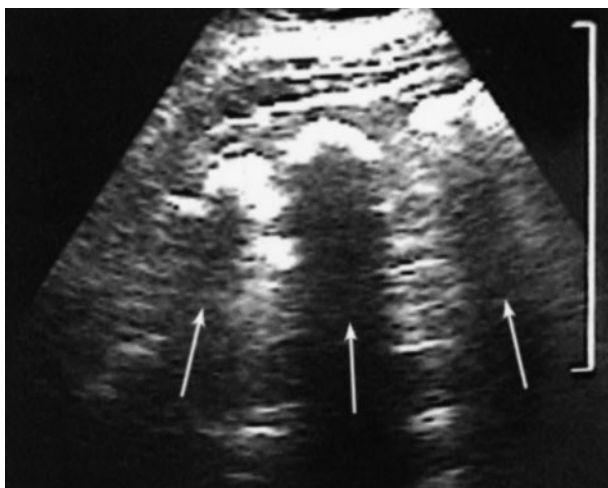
Renal ultrasound showing abnormally echogenic medullary region and acoustic shadows (arrows) beyond the calcifications.
